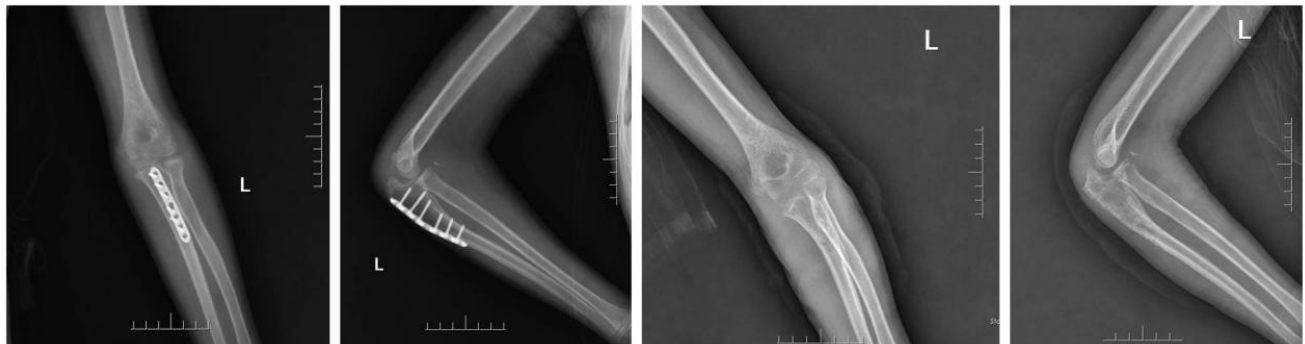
Radiographic confirmation of ulnar union and stable joint alignment after internal fixation removal.
